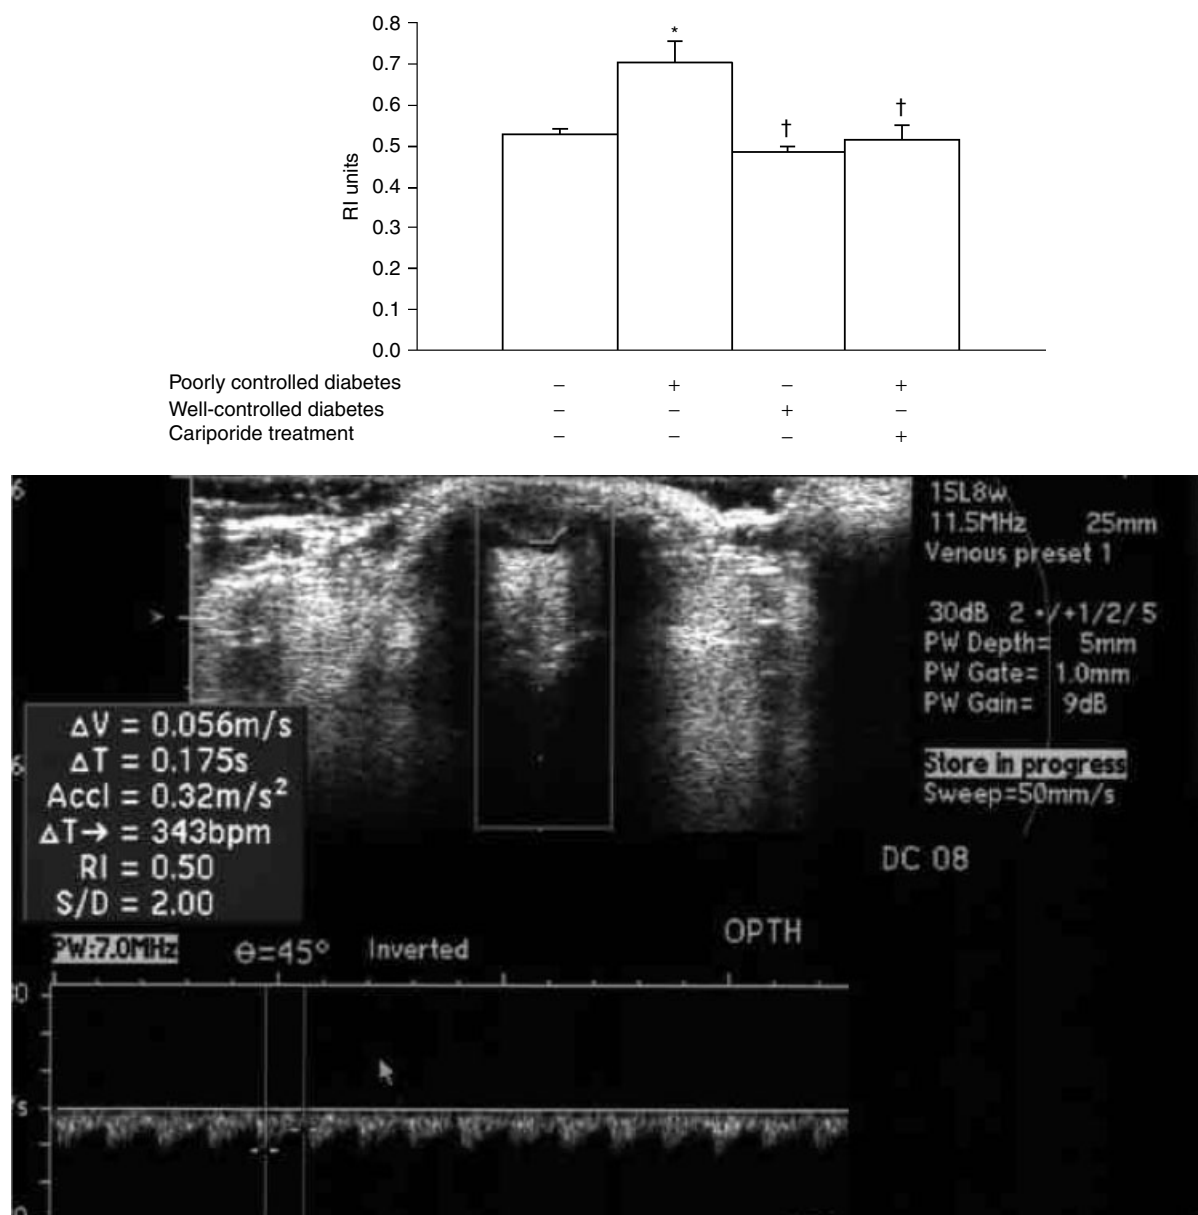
Resistivity index (RI) of the central retinal artery. The upper panel represents the analysis of the mean RI values \pm SEM. The lower panel is a representative color Doppler ultrasound image. RI is calculated from the arterial tracing (please see materials and methods) (* significantly different from nondiabetic control, † significantly different from poorly controlled diabetes. $n = 5$ for all groups)
